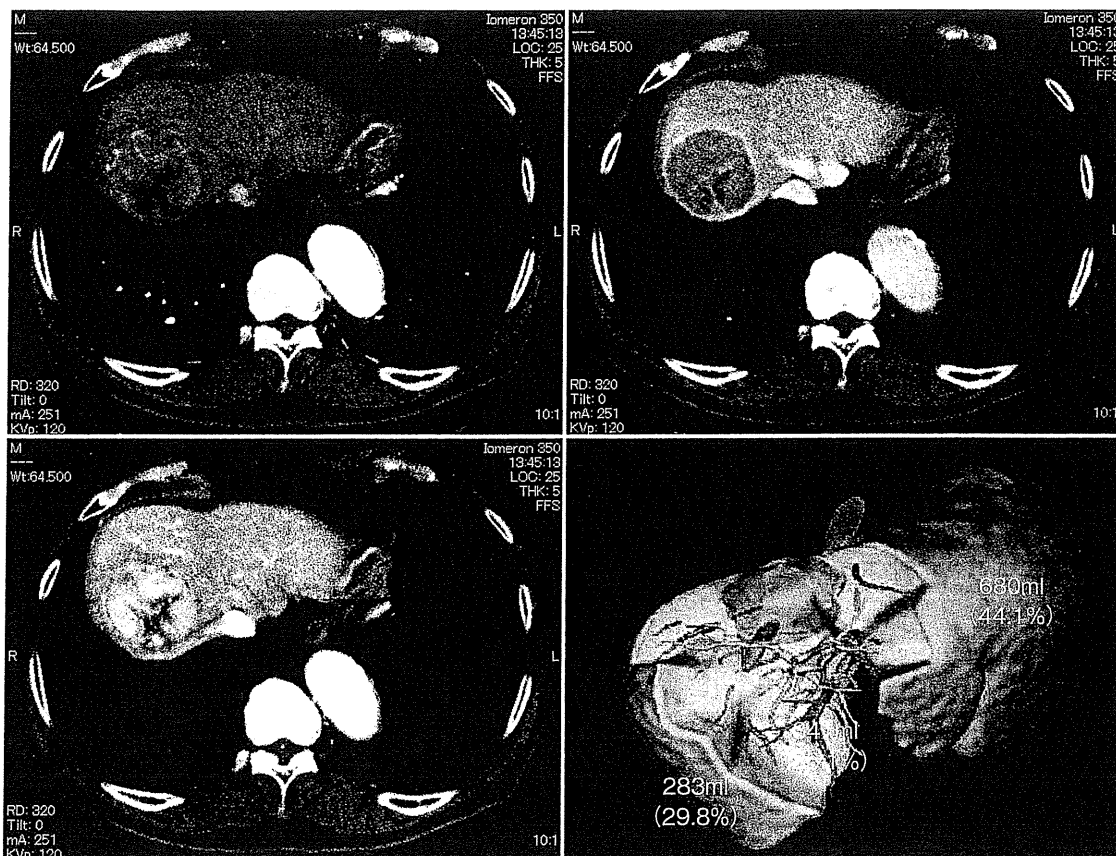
MD-CT より作成した前区域切除の術前シミュレーション
